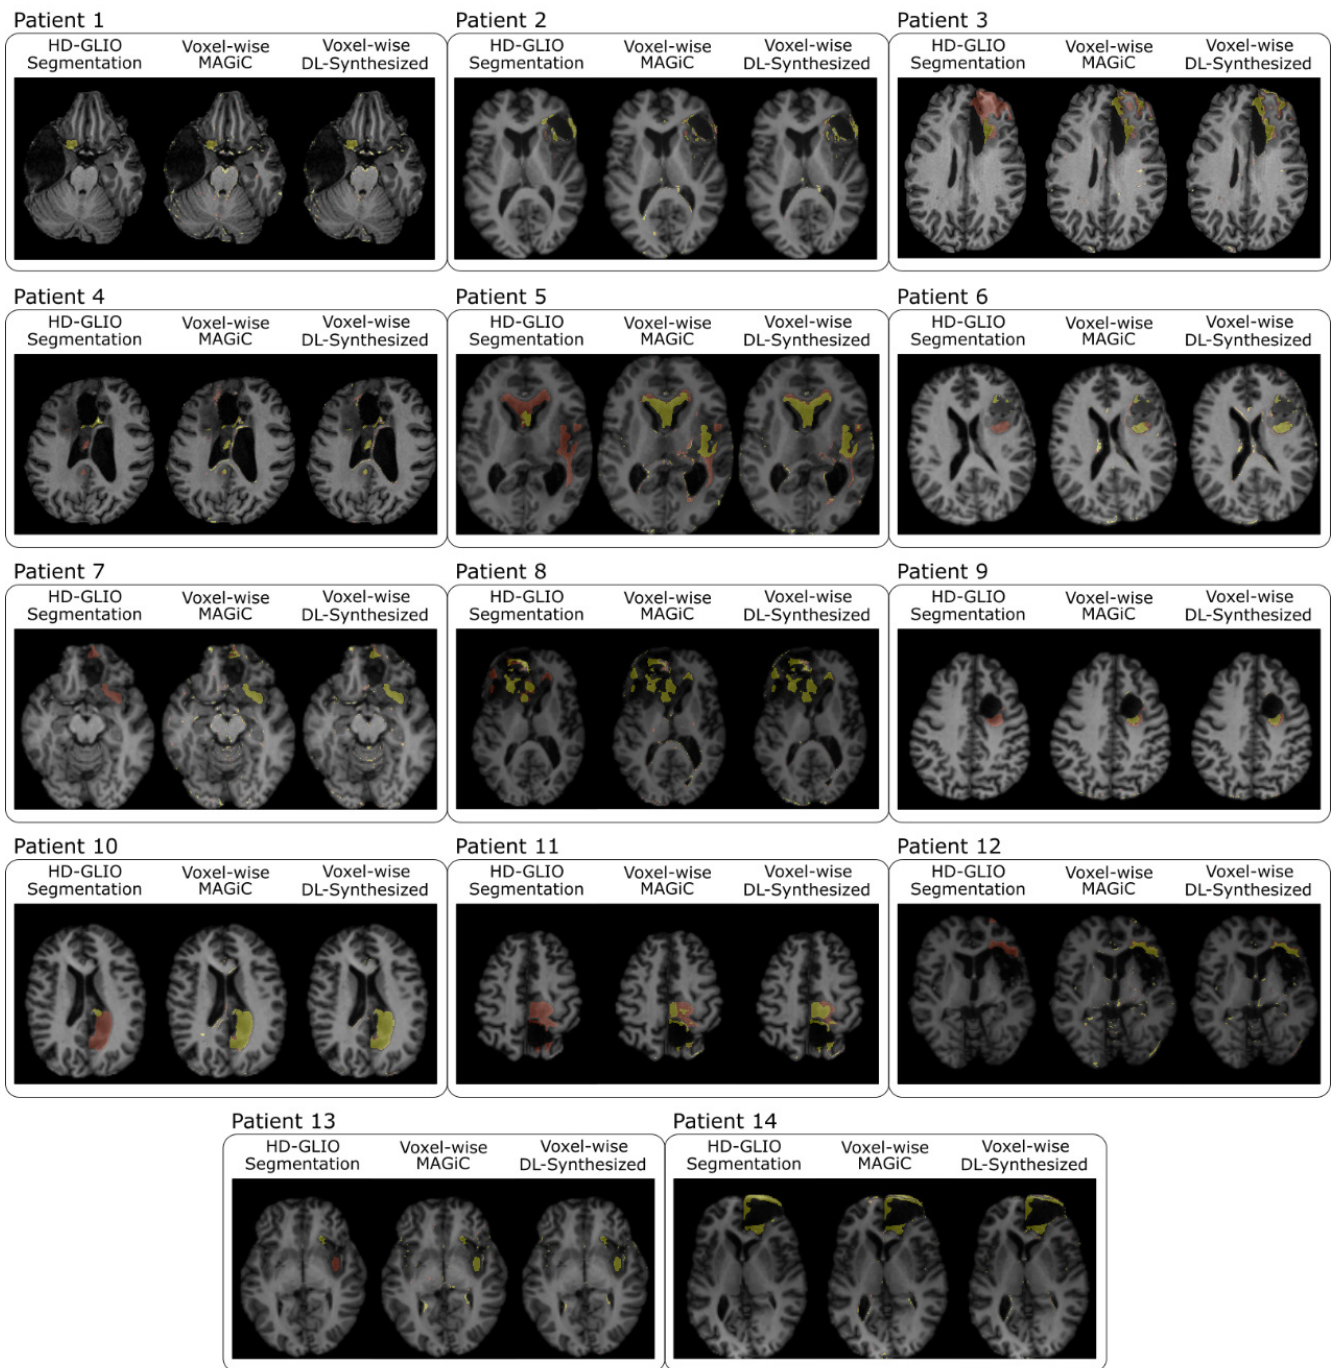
A representative axial slice of the T1e and T2h segmentations overlaid on the pre-T1w images for all the test patients of leave-one-out cross-validation with GLIOMA dataset. For each patient, the ground-truth segmentation obtained with HD-GLIO from the four weighted images, the segmentations obtained through the statistical predictions from MAGiC maps, and the segmentations obtained through the statistical predictions from synthesized maps are shown. MAGiC, magnetic resonance image compilation; T1e, T1w-enhancement; T2h, T2w/T2w-FLAIR signal hyperintensity; T1w, T1-weighted; FLAIR, fluid-attenuated inversion recovery.
